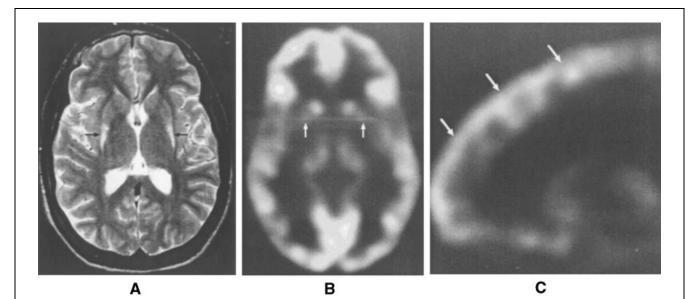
Neuroanatomy and physiology of dystonia. A: Cranial MRI in an 11-year-old Amish boy shows the chronic sequelae of striatal necrosis. In general, the degree of dystonia, and thus long-term neurological prognosis, is directly related to the volume of putamen destroyed (volume loss and gliosis, arrow). B and C: FDG PET in axial (B) and sagittal (C) views shows severe hypometabolism of the dorsal putamen, with small nubbins of functional tissue anteriorly (panel B, red arrows). Caudate metabolism is preserved. There is overactivity of the frontal neocortex (panel C, red arrows). This patient has an abnormal gait and hyperkinetic choreoathetosis, but is able to walk, dress, and eat independently.
